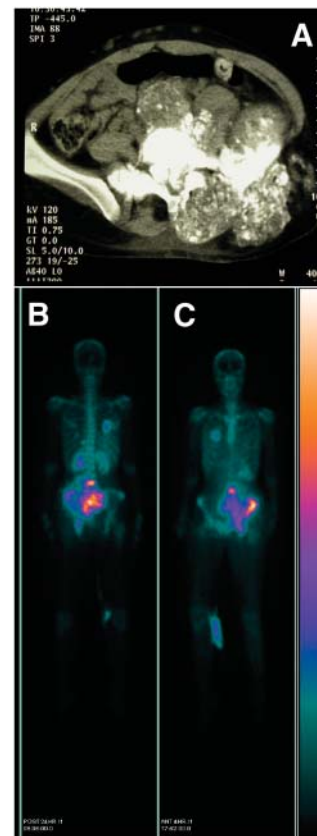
In these images of patient 3, CT transaxial slice through tumor site (top) shows massive tumor in left pelvis, and ^{186}Re -HEDP posttherapy whole-body scan (bottom) shows heterogeneous but intense uptake at tumor site in both posterior (left) and anterior (right) views. In addition, metastases are noted in right lung field, L4 vertebra, and left ribs posteriorly.
